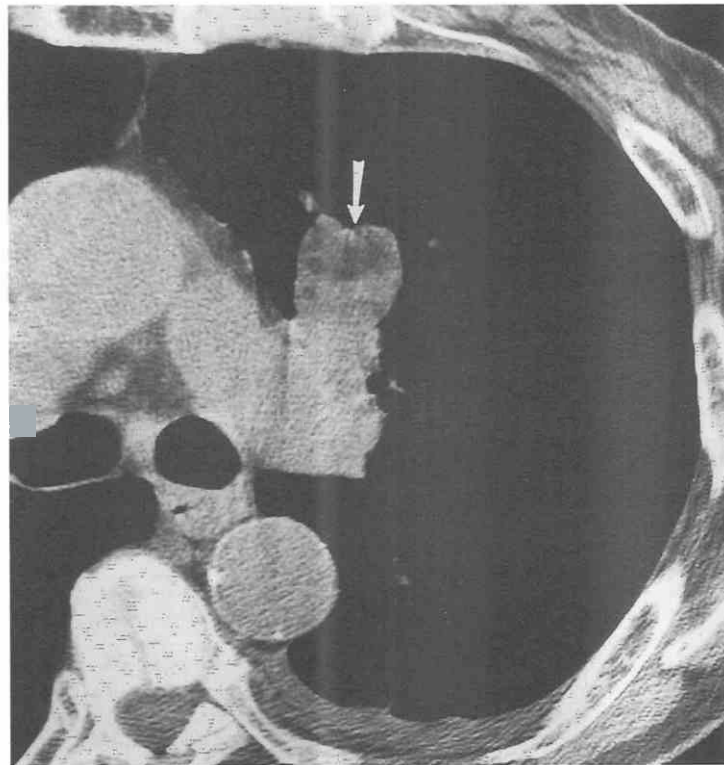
Hamartoma appearing as a solitary pulmonary nodule. CT shows a left upper lobe nodule (arrow) anterior to the left pulmonary artery. The diagnosis is suggested by small areas of fat (attenuation, -41 Hounsfield units) within the nodule.
